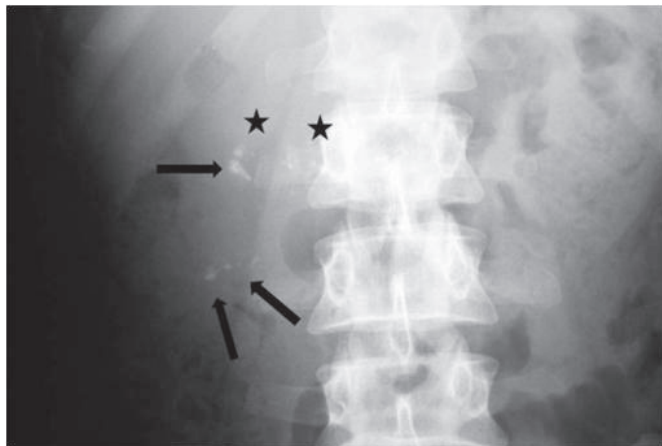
Plain X-ray abdomen showing pancreatic ductal calcification (stars) and arc-like calcification (arrows) in the pancreatic head region
